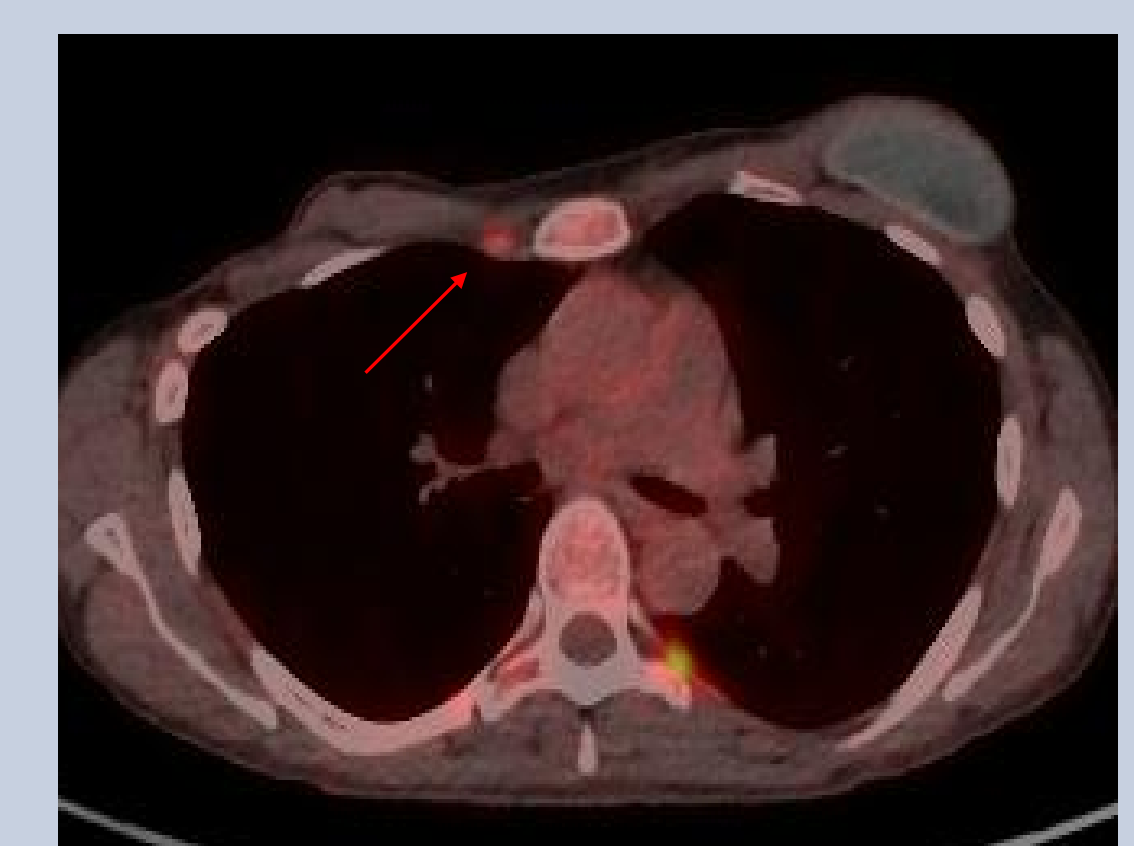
PET-CT demonstrating low uptake in a right internal mammary lymph node
